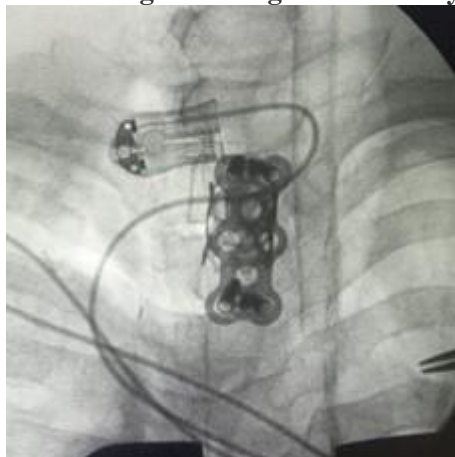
Postoperative Xray Image Ap View Showing Plate and Pyra Mesh Fixation of T1 To T3 Vertebra
